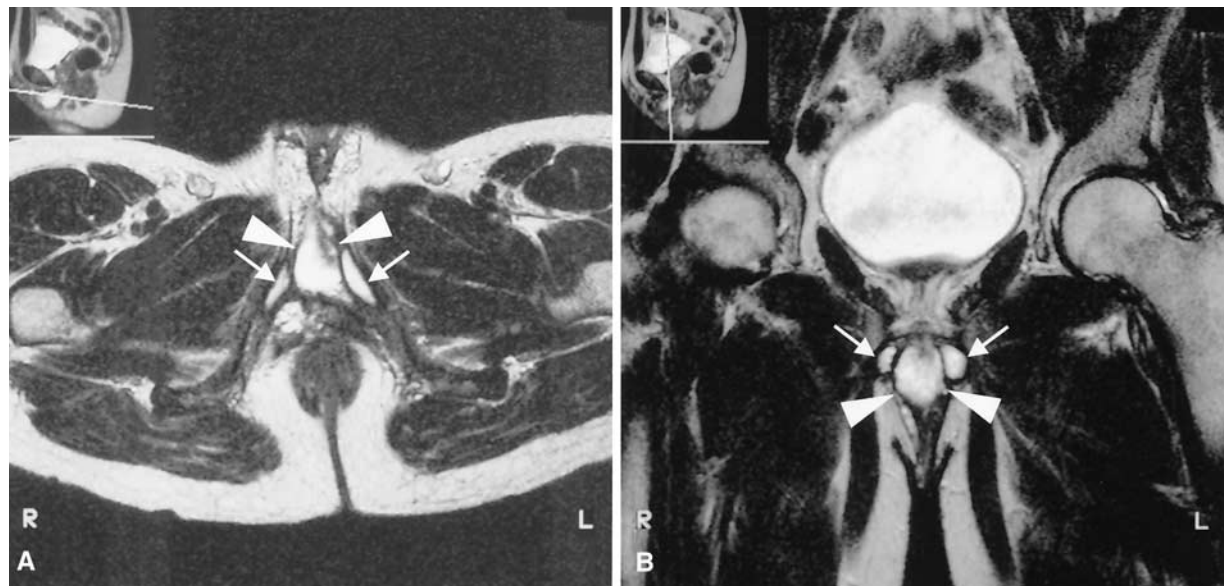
Axial (A) and coronal (B) turbo spin-echo T2-weighted images show remnants of the corpora cavernosa (arrows) and the urethral corpus spongiosum (arrowheads).
